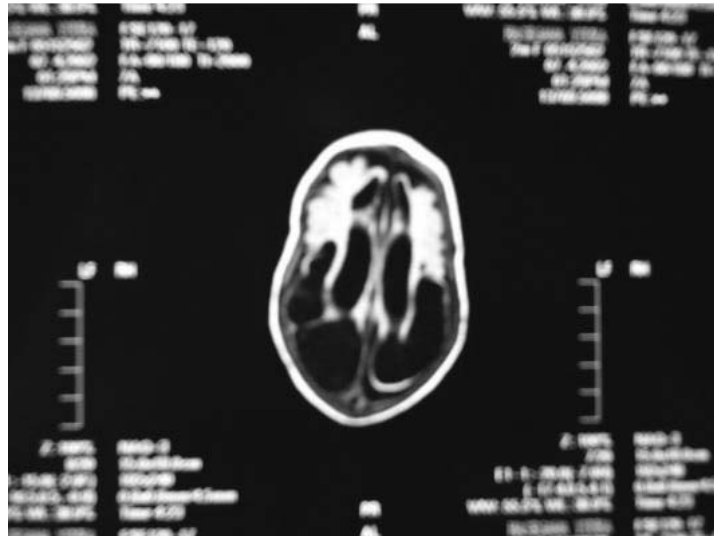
Follow-up MRI brain scan. Follow-up MRI brain scan of the patient at the age of two months showed multicystic encephalomalacia
